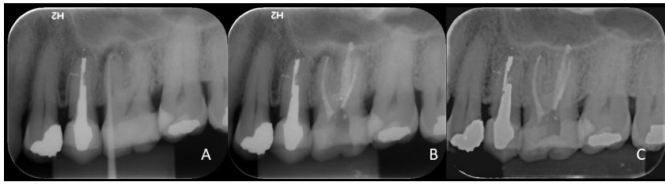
Radiographic features of the presented case (A). Fistulous path tracking showing relation with teeth 16 (B). Immediate post-operative radiography after endodontic treatment (C).
